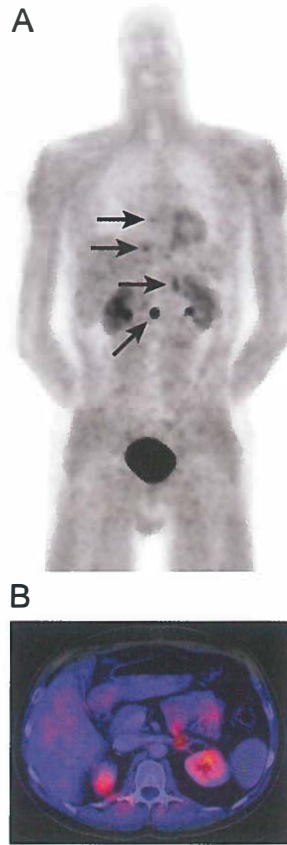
Imaging of a patient with a known metastatic pheochromocytoma. (A) ^{18}F -DOPA PET shows increased uptake in the left adrenal gland and three lesions in the spine (arrows). (B) Fusion image of ^{18}F -DOPA PET and CT shows uptake in the region of the left adrenal gland, without anatomical substrate. (C) CT image of the region of the left adrenal gland. ^{123}I -MIBG imaging was negative (not shown).
